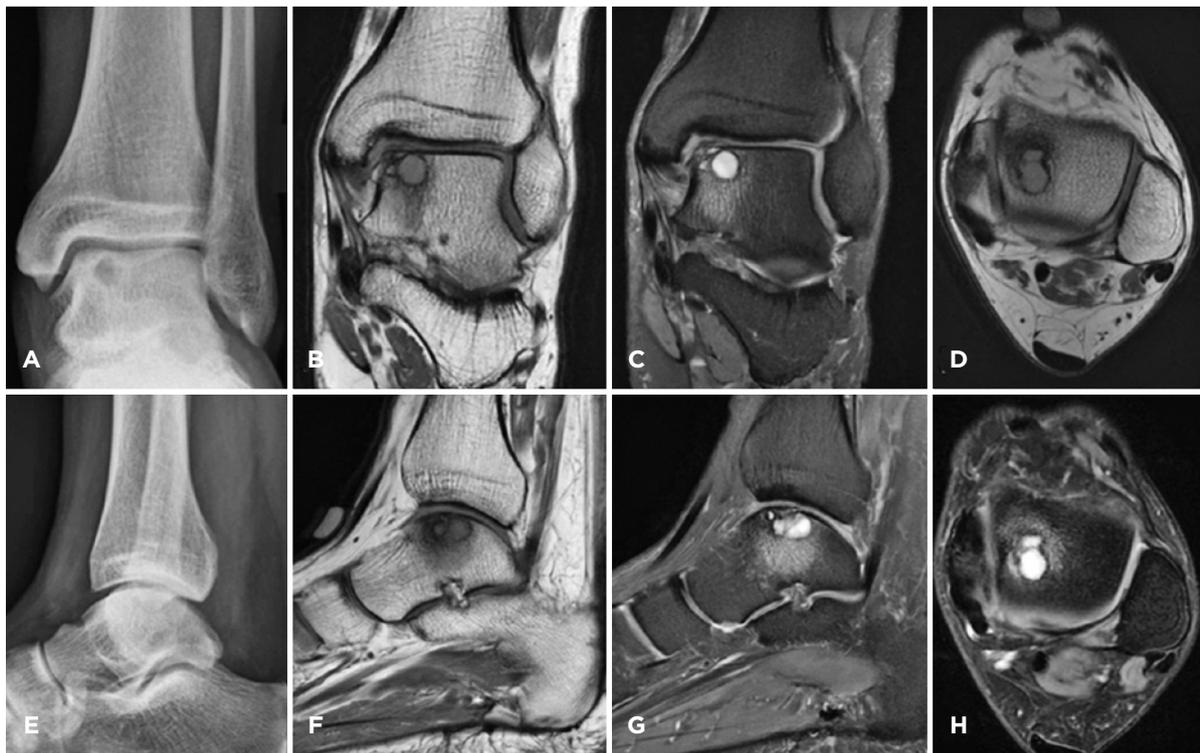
Images of a patient with osteochondral lesions of the talus (Raikin's area 4) with important "prognostic complicating factors": the lesion size, involvement of the shoulder of the talus (unstable lesion), and subchondral cysts. Observing the intense bone marrow edema around the lesion is important, as it is characterized by signal changes on both T1 and T2 images. (A) AP and (E) Lateral - plain ankle radiographs; (B) T1 and (C) T2 coronal views; (F) T1 and (G) T2 sagittal views; (D) T1 and (H) T2, transverse views.
